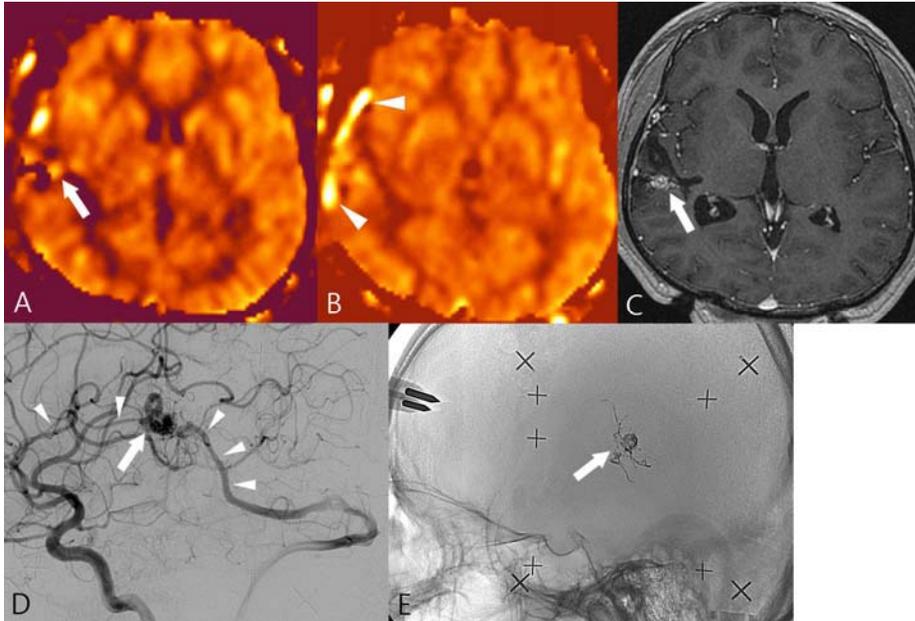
A 30-year-old male with left homonymous hemianopsia. (A and B) Axial ASL images. There is a tiny asymmetric high signal intensity adjacent to the signal void area in the right temporal lobe (A, arrow). One of the reviewers overlooked this intensity but detected a serpiginous high signal intensity along the location of cortical vein in the right temporal lobe (B, arrowheads), which he determined was a venous signal. After discussion, the two reviewers concluded that the high signal intensity in the right frontal lobe (A) represented a nidus signal. (C) Axial T1-weighted post-contrast image shows a small enhancing vascular lesion (arrow) in the right temporal lobe. (D) Lateral DSA confirms a temporal AVM (arrow) fed by multiple feeders originating from the right MCA and engorged veins (arrowheads) draining into the sphenoparietal and transverse sinus. E, Lateral plain radiograph shows a radiopaque cast in the corresponding area (arrow). The patient had previously undergone endovascular embolization using Onyx (not shown).
